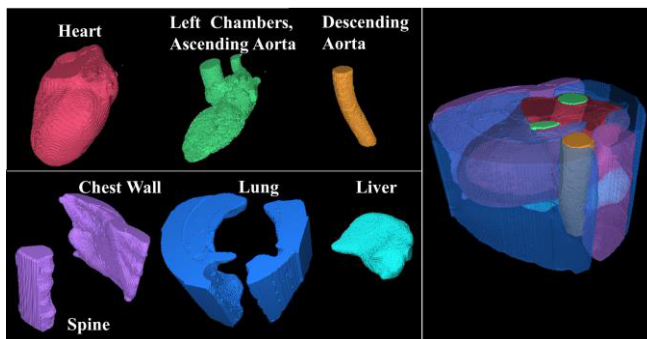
3D multi-color render of different tissue structures in a cardiac CT volume segmented by the proposed algorithm.
